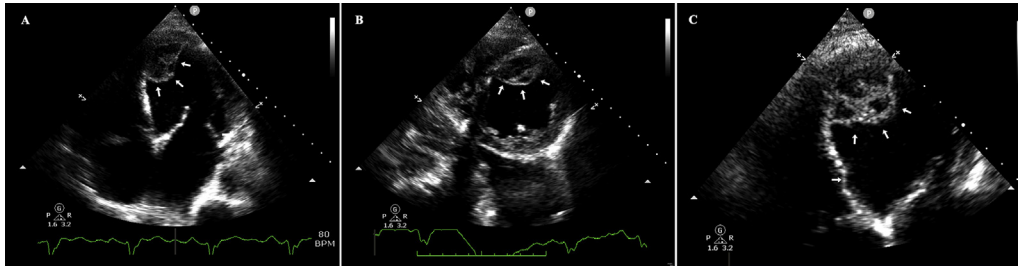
Transthoracic echocardiography images showing apical thrombus with multiple internal hypoechoic regions. Panel A: Apical four-chamber view; Panel B: parasternal short-axis view; Panel C: Zoomed apical two-chamber view.
